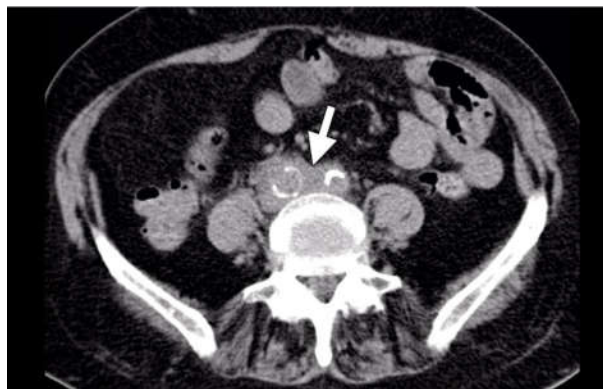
CT Non Contrast Axial view of retroperitoneal fibrosis
